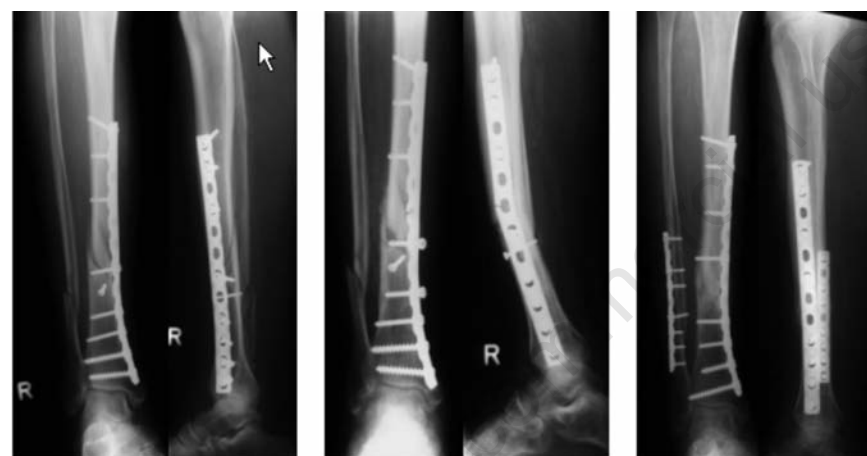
Plate failure: postoperative radiographs (left), at six weeks (middle), and after revision surgery (right). Note that the principles of dynamic plate osteosynthesis were not respected during the primary procedure by inserting a lag screw through the plate. Plate breakage was recorded at six weeks. Fracture healing was achieved after revision surgery with replacement of the plate, additional osteosynthesis of the fibula to provide lateral support, and removal of the lag screw to allow micromotion.
